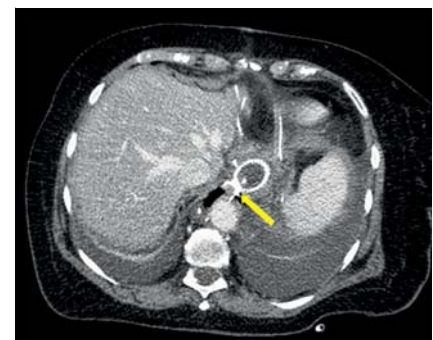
Computed tomography scan showing the implanted esophageal stent and the rotated branch protruding toward the aorta (yellow arrow).
